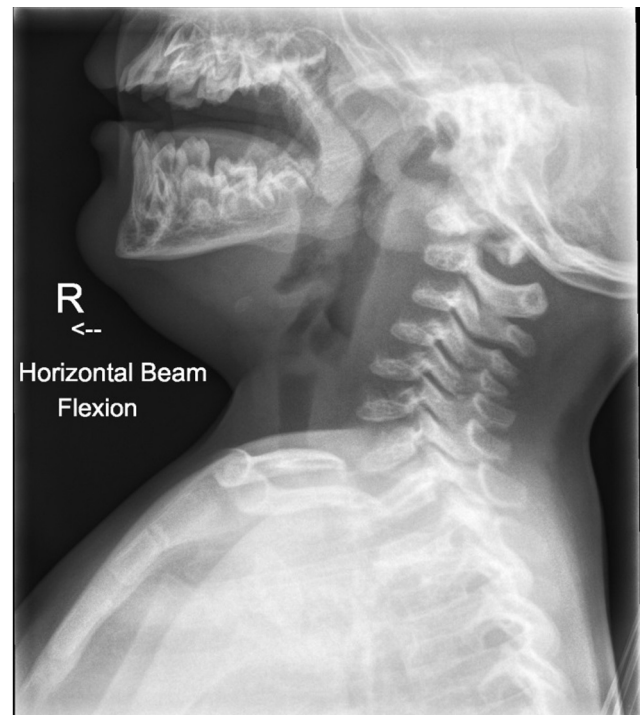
Dynamic radiographs showing C1–C2 instability in a 2-year-old with Morquio syndrome.
